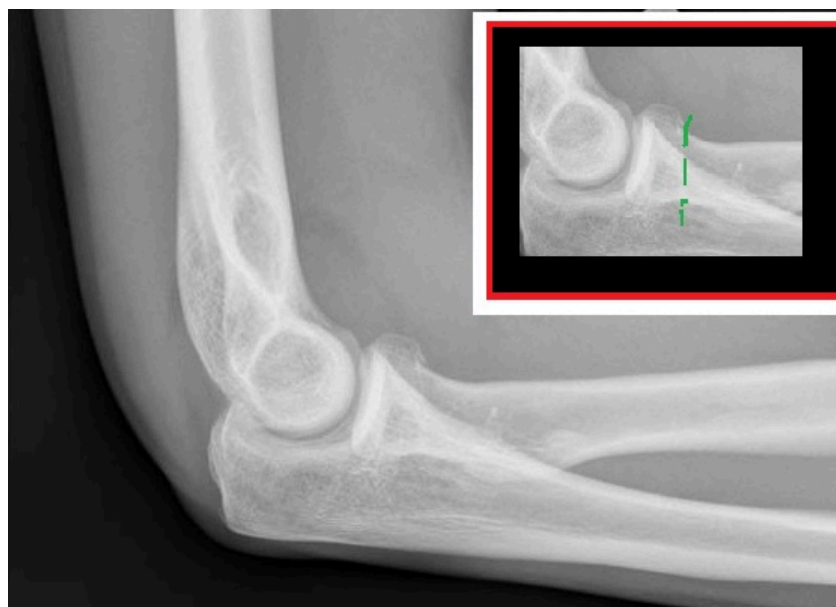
Radiograph of Mason Type 1 radial head fracture (fracture line shown in green). (from radiopaedia <http://bit.ly/1Q7URwP>)
